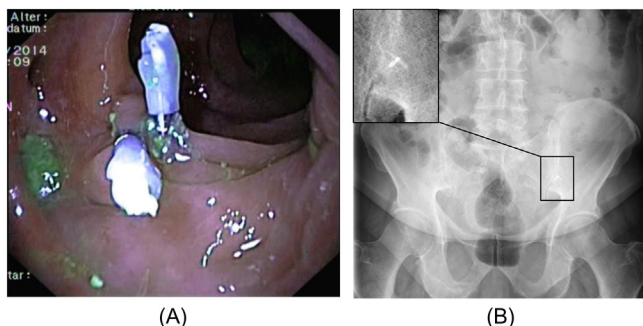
(A) Intracolonic clips marking the lesion which has to be resected. (B) Plain abdominal X-ray: The tiny clips are barely visible. Inset: Even under magnification the accurate site of the lesion is difficult to define. *All: Courtesy: PD Dr. D. Wilhelm, Klinikum rechts der Isar.*
